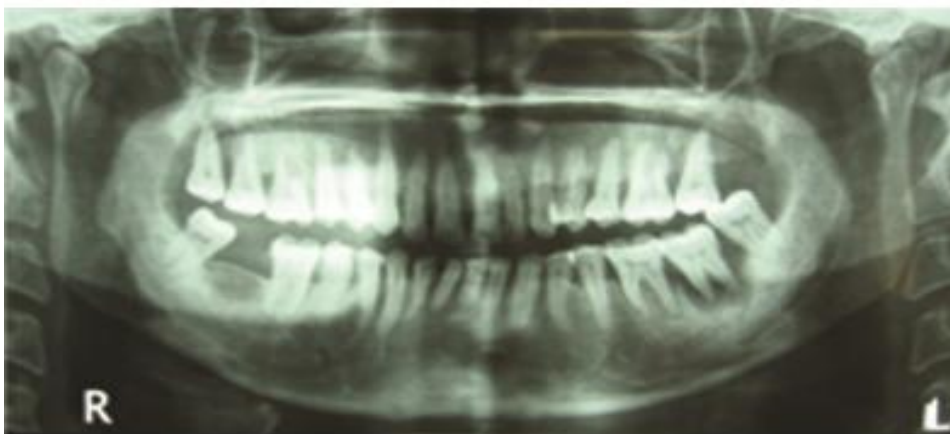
Orthopantomograph shows periodontal abscess irt 37
